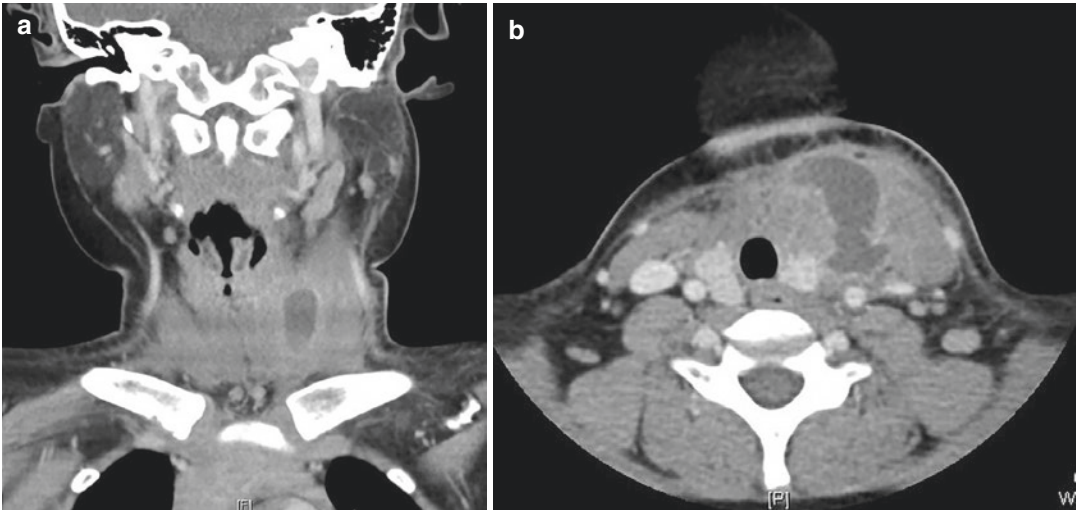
Head and neck CT scan for the second episode revealed an irregular rim-enhancing fluid collection in the left neck abutting the left thyroid gland in coronal plane (a) and axial plane (b)
